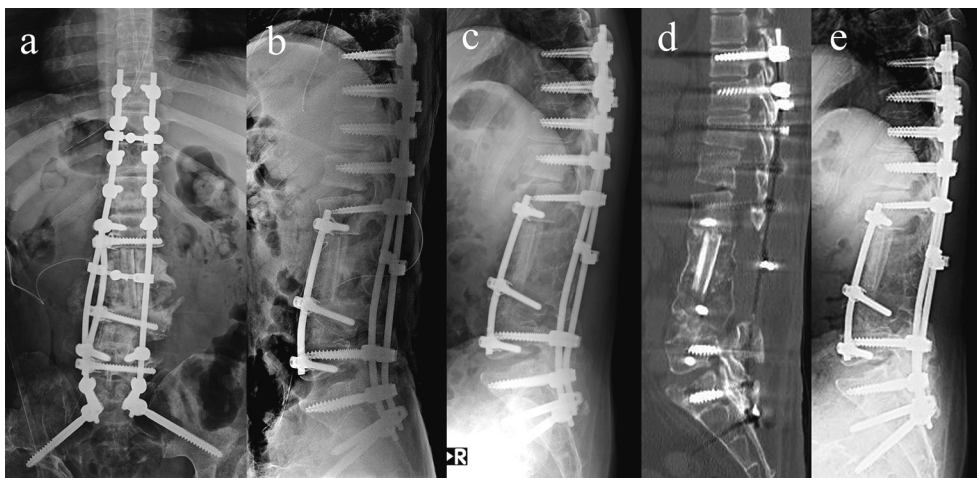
Thoracolumbar images after a posterior long-fusion and anterior fusion with autologous bone grafts. Anteroposterior (a) and lateral (b) radiograms just after the surgery at the age of 31. Lateral radiogram (c) and sagittal section of computed tomography image (d) at 1.5 years after surgery at the age of 32. (e) Lateral radiogram at 2.5 years after surgery at the age of 34.
